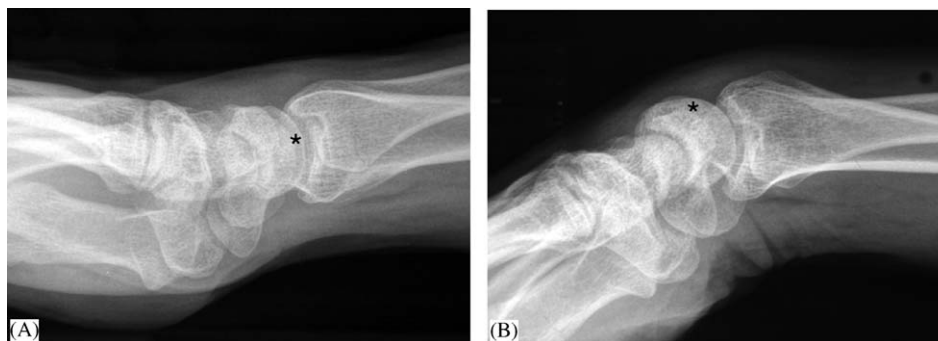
X-rays of lateral views of the wrist in neutral (A) and in palmar flexion (B). The asterisk (*) symbol in both the views indicates the position of the lunate and the proximal pole of scaphoid with the scapholunate junction in between them, and they are more prominent with the wrist in flexion.
